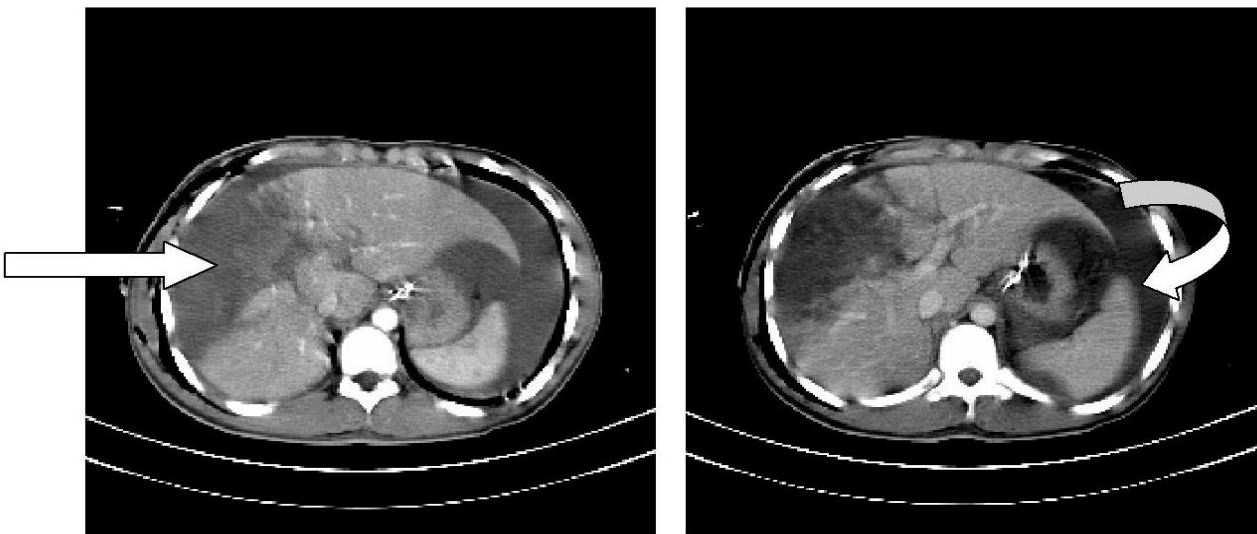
FIGURE # 17 : CONTRAST ENHANCED CT ABDOMEN AXIAL SECTIONS OF ARTERIAL AND VENOUS PHASE SHOWING LARGE ILL-DEFINED NON-ENHANCING HYPODENSE LESION INVOLVING RIGHT LOBE OF LIVER(ARROW) WITH ASCITES(CURVED ARROW)
